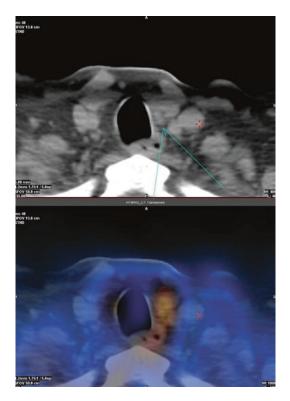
Tc-99m-sestamibi parathyroid SPECT-CT scans showing left superior lobe parathyroid adenoma
